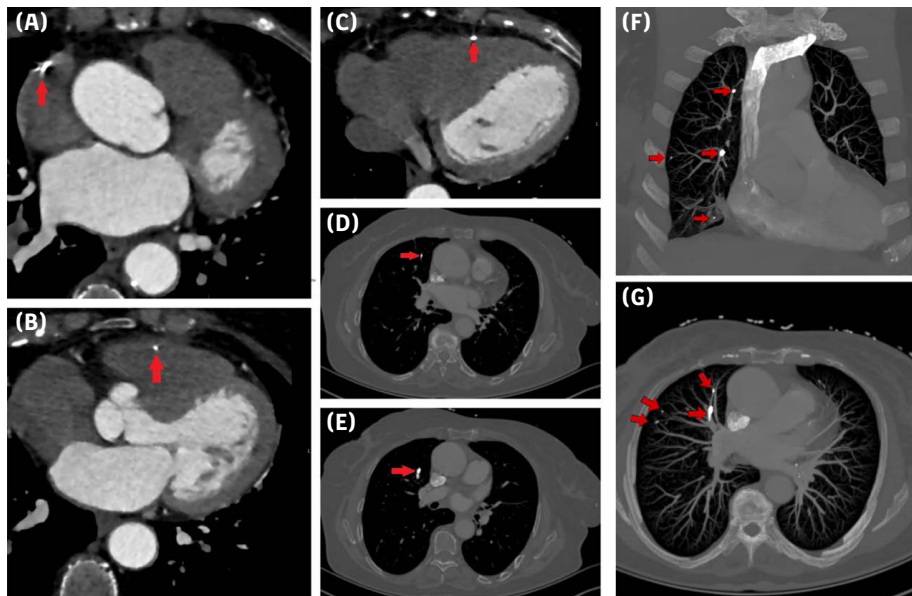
Cardiac and Pulmonary CT, arrows demonstrate multiple hyperdense foci compatible with cement embolism. (A) Right atrial cement pieces, (B, C) Right ventricular cement pieces, (D, E) Pulmonary cement embolism, (F, G) Axial and coronal bone window MIP images.
